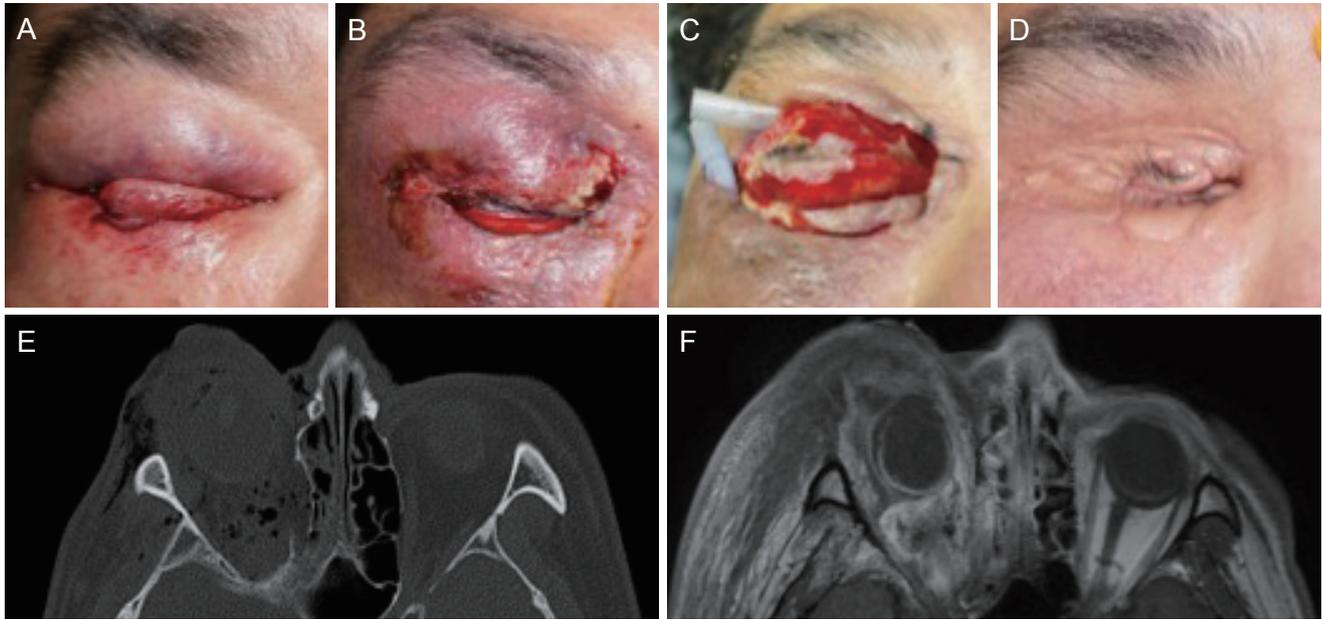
Case 1. Serial photographs and images of the patient. (A) The day of injury, wound irrigation with antibiotics mixed with saline and systemic antibiotics were administered. (B) Three days after starting systemic steroid treatment. (C) Two weeks after the injury, irrigation and drainage were performed on three separate occasions. (D) Six months after the injury. (E) Computed tomography scan the day of injury, showing multiple oil droplets in the right orbit. (F) Orbital magnetic resonance image the day after the injury. Soft tissue swelling and inflammation of the right face were present with a worsening orbit. A change in eyeball contour was observed due to intraorbital pressure.
